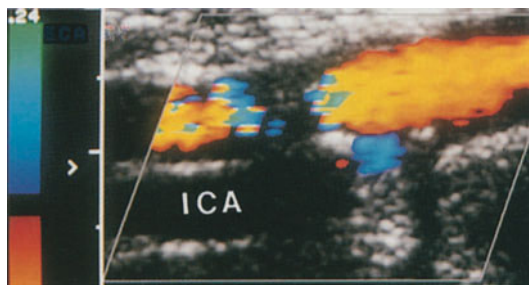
No color flow within the ICA lumen can be demonstrated in this longitudinal sonogram, indicating occlusion of the vessel. Flow reversal is shown proximal to the occlusion. A medium-grade stenosis of the ECA is also displayed
